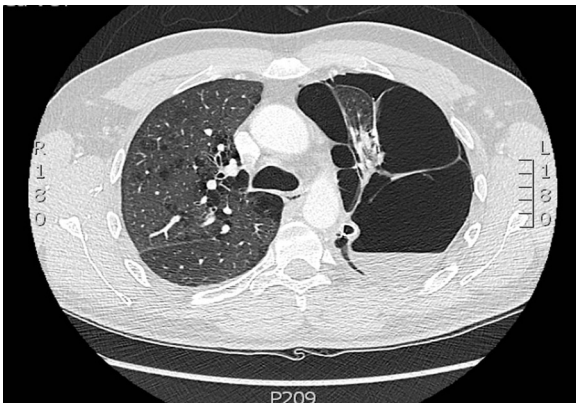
CT thorax showing a large left sided hydropneumothorax and giant bullae. Right lung was normal.
